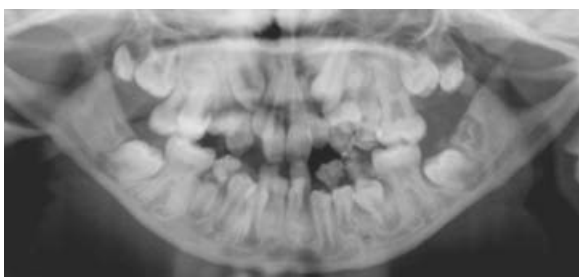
Orthopantomogram demonstrating supernumerary teeth. These required multiple extractions
